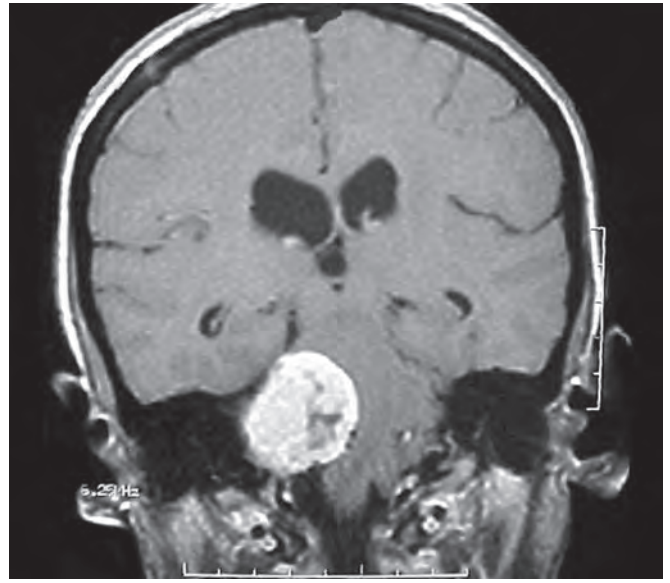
Contrast magnetic resonance imaging of the brain T1W coronal view showing enhancing vestibular schwannoma
